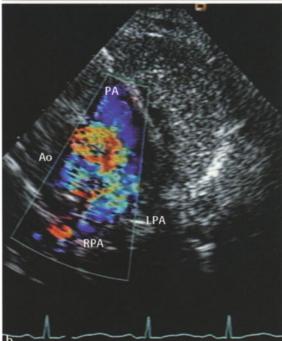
Echocardiography. a Parasternal short-axis view showing the large aortopulmonary window (white arrows), b parasternal short-axis view showing view of the same patient as in a showing the color Doppler investigation with left-to-right shunt through the unrestrictive aortopulmonary window (*Ao* aorta, *LPA* left pulmonary artery, *PA* pulmonary artery, *RPA* right pulmonary artery) (photographs courtesy of Dr. Nicole Sekarski)
